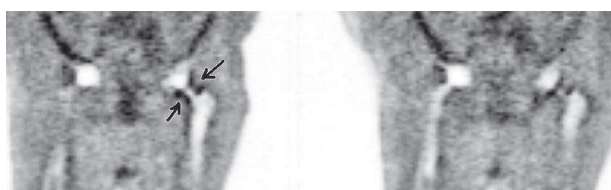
18F-FDG-PET in patient number 1 (male, 79 years) with an asymptomatic 2-year history of bilateral hip prosthesis shows enhanced uptake in the left neck region (arrows).
